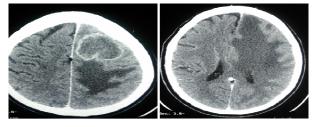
CT scan taken after course of antibiotic showing worsening of perilesional edema with significant mass effect and ring enhancing lesion
